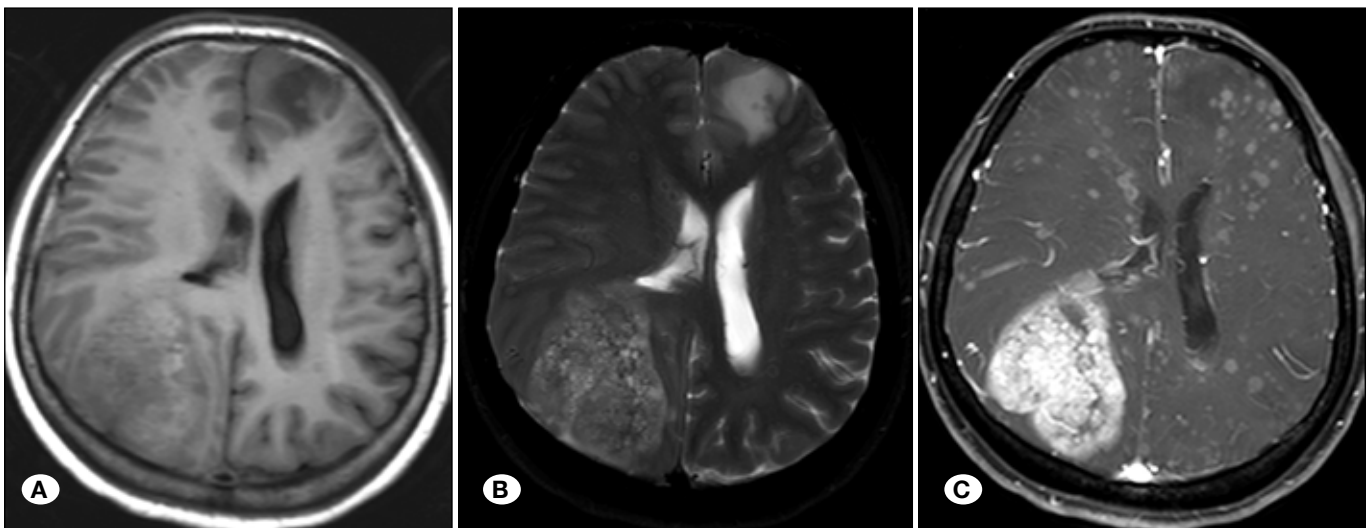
The MR imaging of a 45-year-old female with a history of lung carcinoma. A) T1WI, B) T2WI, C) contrast-enhanced T1WI. A huge mass with heterogeneous hypointensities on T1WI and non-uniform hyperintensities on T2WI was located in the right occipital lobe. On contrast-enhanced T1WI, an enhanced huge mass and multiple dispersed cysts with ring-like enhancement were seen. These lesions were all considered metastases, however, pathology surprisingly revealed the right occipital lesion to be metastatic adenocarcinoma and the adjacent small nodules to be parenchymal NCC.
